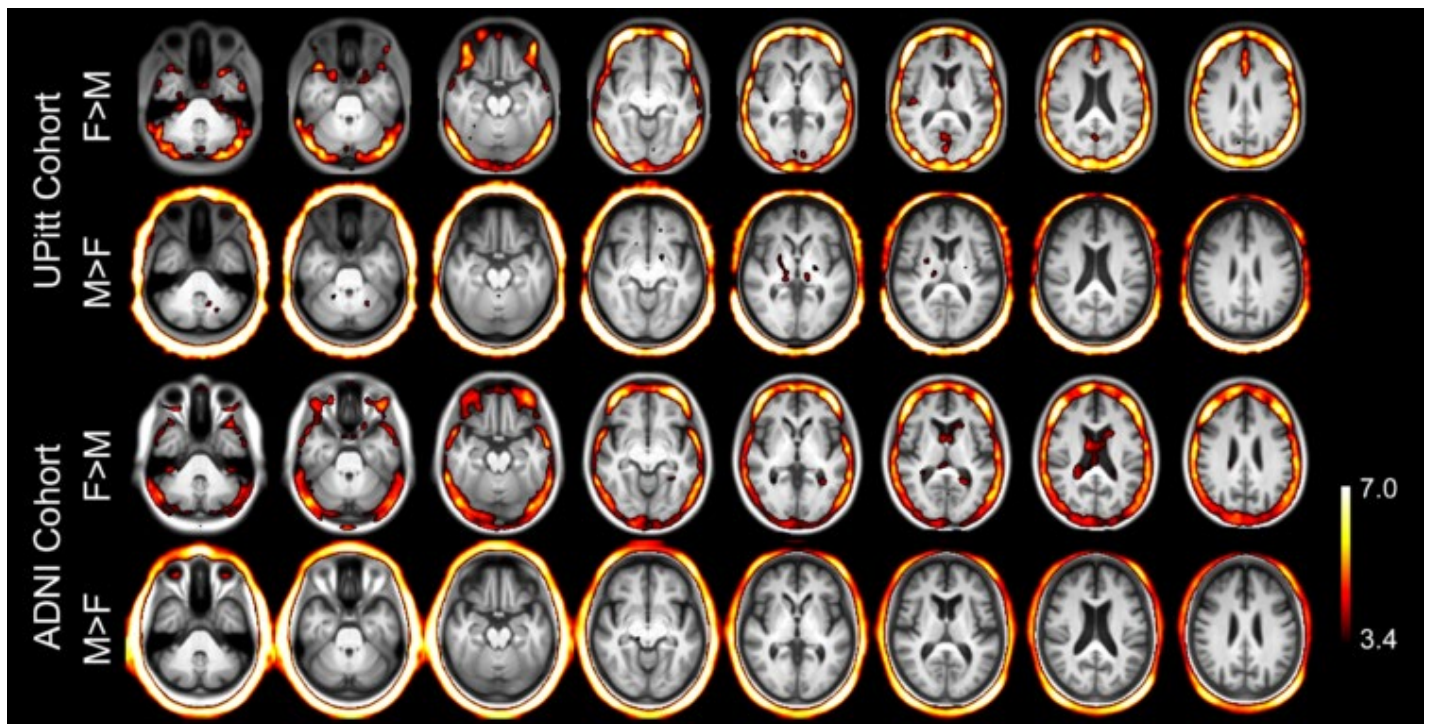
T-score maps of sex-related differences in [¹⁸F]AV-1451 SUVR overlaid on cohort-specific average MR images. A t-score of 3.4 corresponds to an uncorrected *p*-value of 0.0005 in both cohorts. T-scores of 5.4 and 4.9 correspond to FWE-corrected *p*-values of 0.05 for the UPitt cohort and ADNI cohort, respectively.
